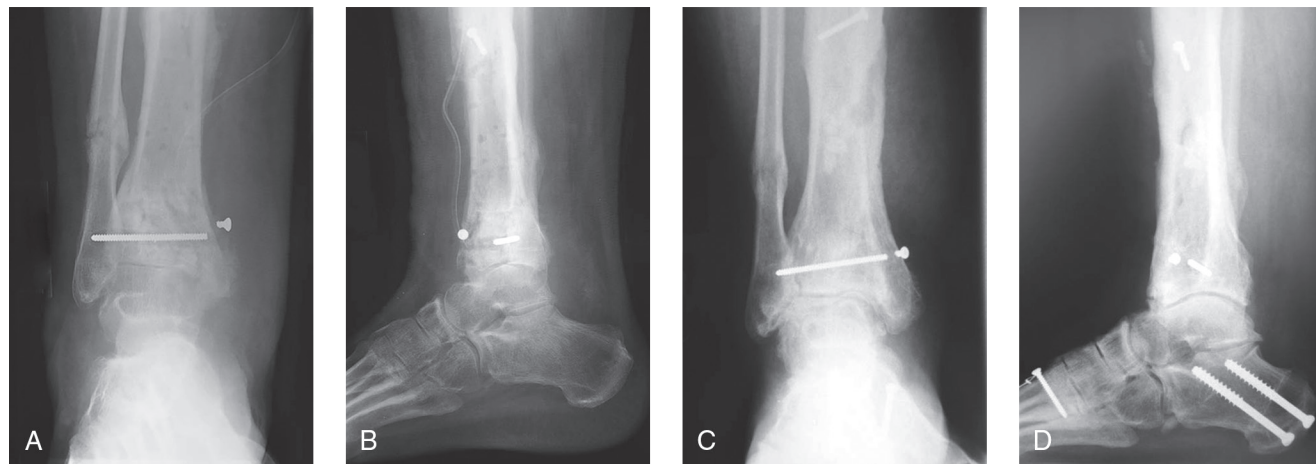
Weight-bearing AP (A) and lateral (B) radiographs of the right ankle of a 25-year-old patient demonstrate severe posttraumatic ankle arthritis following open pilon and distal tibia shaft fractures. The patient sustained substantial damage to the soft-tissue envelope surrounding the distal tibia. Note underlying cavovarus foot posture. AP (C) and lateral (D) radiographs of the same patient obtained 8 years after ankle distraction, cavovarus foot reconstruction, and management of localized distal tibia osteomyelitis. The patient was able to return to work in an occupation requiring considerable walking and experienced substantial improvement in pain level and function.
